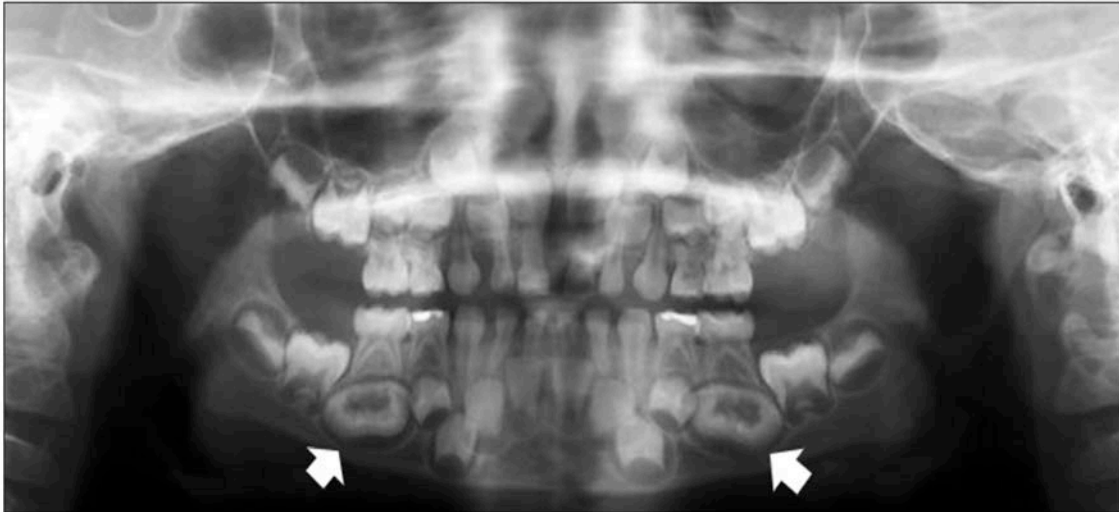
Panoramic radiograph with developing dilated odontomes of mandibular premolar teeth #20 & #29.
